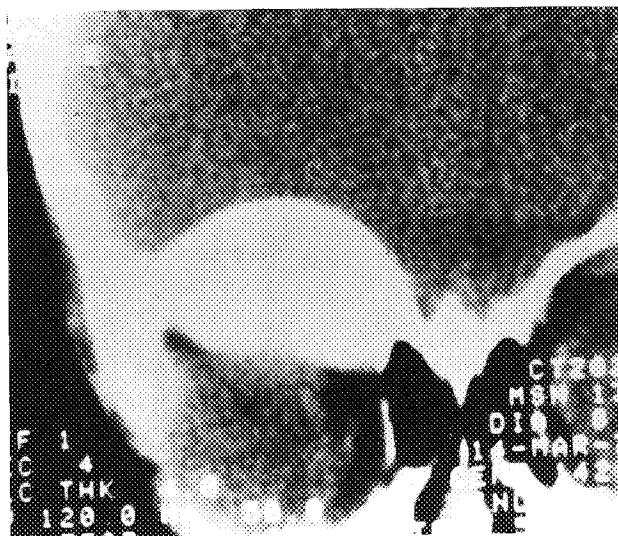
CT scan shows fibrous dysplasia of the right frontal bone resulting in sclerotic thickening of the orbital roof, resulting in proptosis and downward displacement of the globe.
